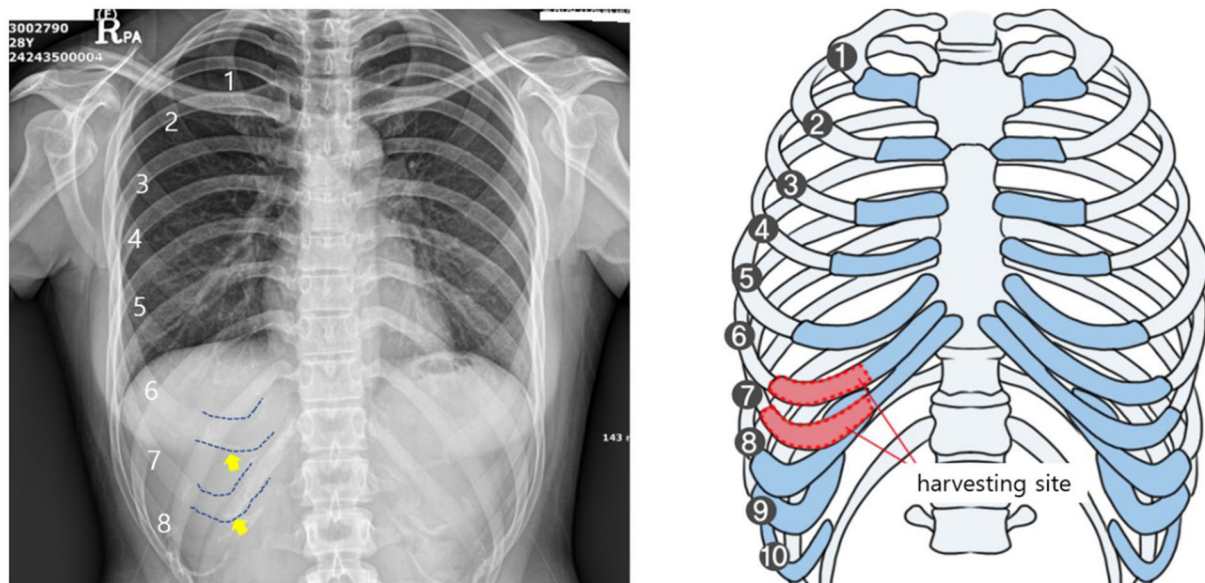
Appropriate number of rib cartilages are assessed on a simple rib series X-ray. Shape, curvature, width and calcification can be reviewed. Dotted lines show curvature, shape, and width of rib cartilages. Yellow arrow shows linear marginal calcification on the 6th rib while granular type on the 7th
